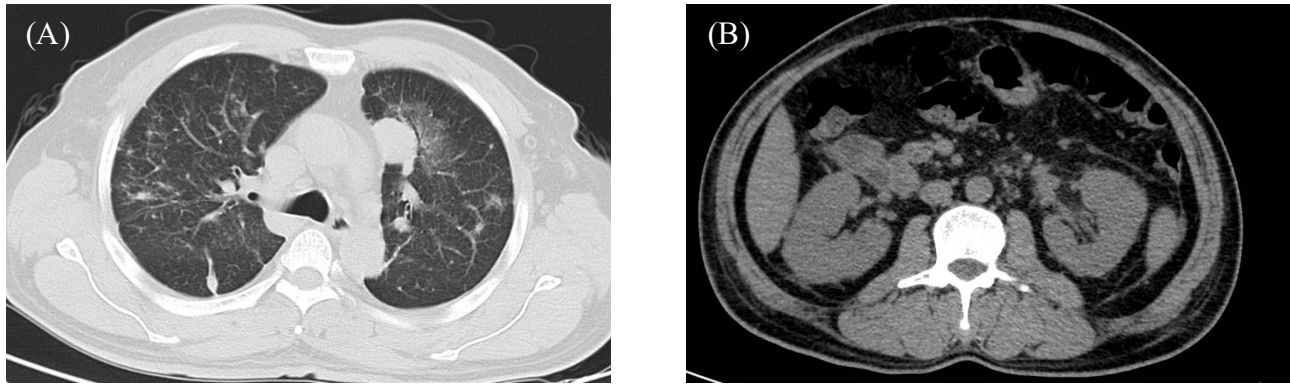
(A) Chest CT showing patchy blurred shadows and multiple small nodular shadows in both lungs. A nodule approximately 25 mm in diameter was observed near the mediastinum of the left upper lung without distinct spiculations. Small bilateral pleural effusions and adjacent lung parenchyma were noted. The trachea and main bronchial branches were patent, and no enlarged lymph nodes were found in the bilateral hilum or mediastinum. (B) Abdominal CT showing bilateral perirenal exudation, thickened fascia, slight effusion in the left paracolic groove, slight dilation of the left ureter's upper segment, peripheral exudation, and slight effusion in the pelvic cavity
